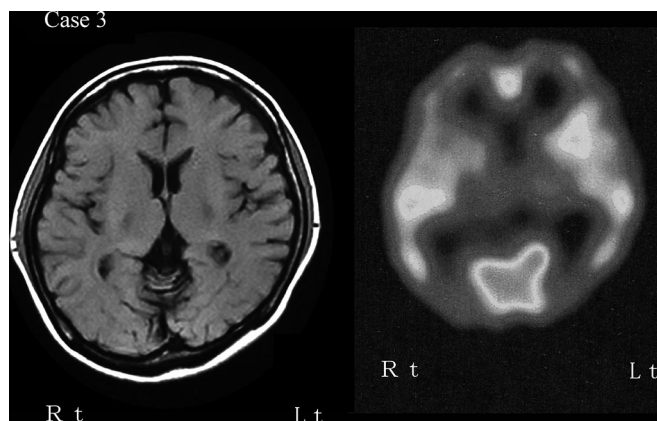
MRI and SPECT findings of case 3. Left: T1-weighted MR image (TR/TE = 450/18.0 milliseconds). Right: ECD-SPECT.
